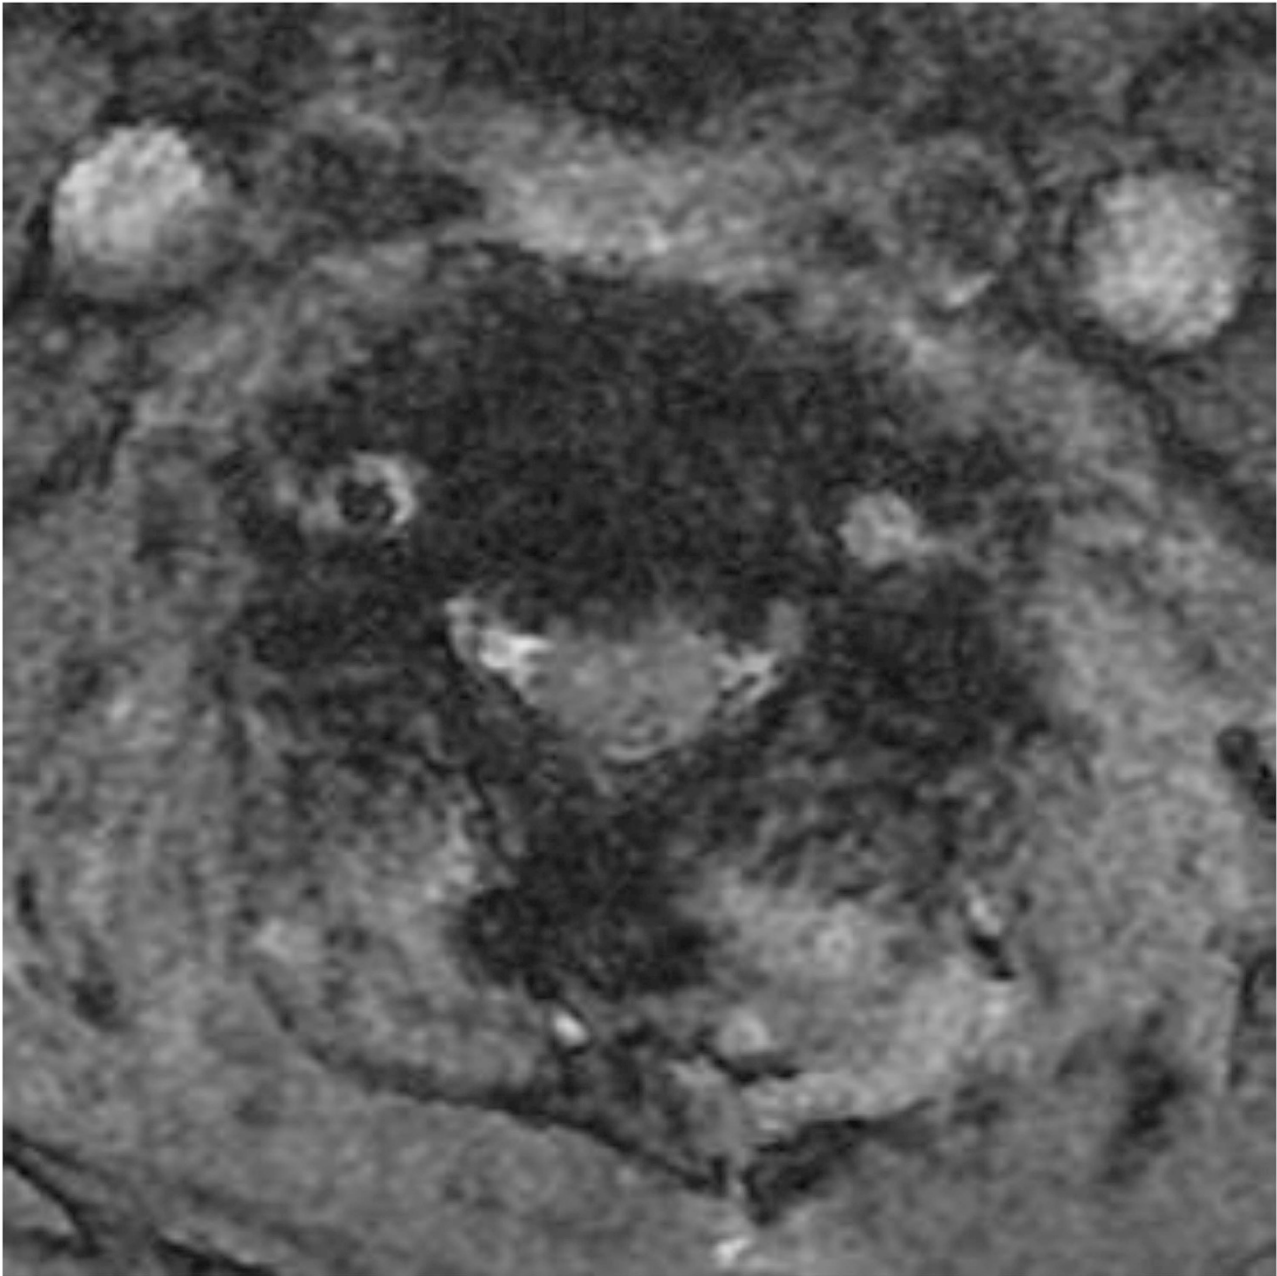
MR images of the cervical spine at the initial visit to the previous hospital. Right side vertebral artery maintained the blood flow.
